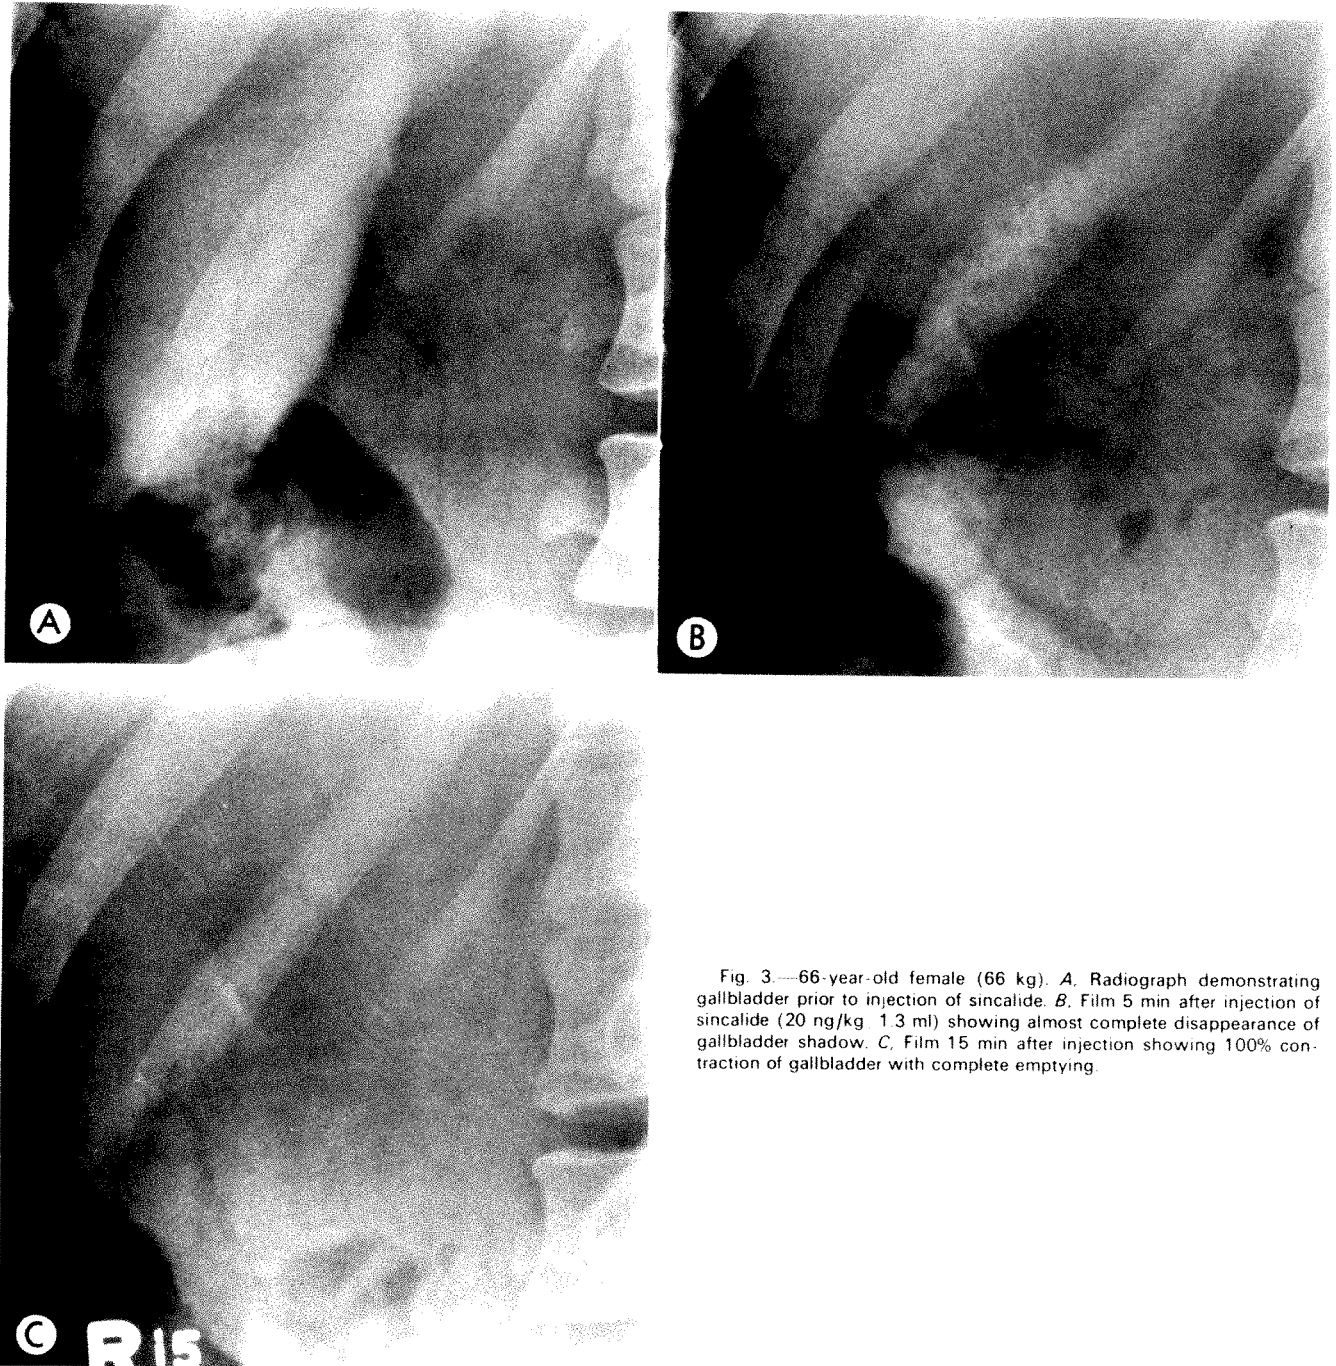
66-year-old female (66 kg). A, Radiograph demonstrating gallbladder prior to injection of sincalide. B, Film 5 min after injection of sincalide (20 ng/kg, 1.3 ml) showing almost complete disappearance of gallbladder shadow. C, Film 15 min after injection showing 100% contraction of gallbladder with complete emptying.
